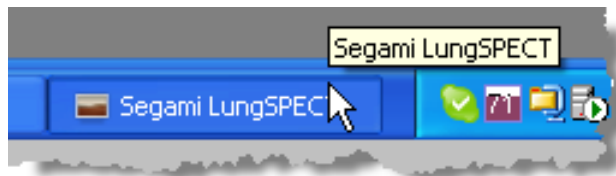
The Segami LungSPECT task bar item.
